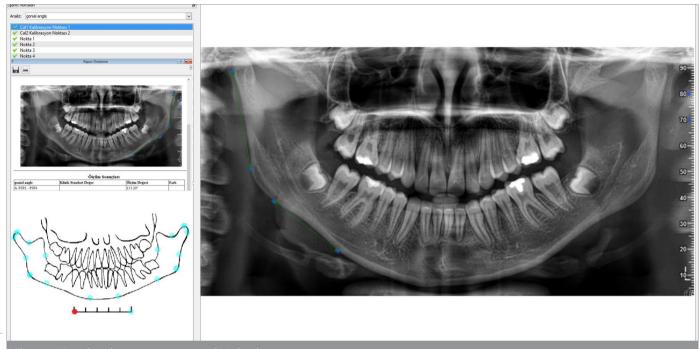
Gonial angle measurement on a digital orthopantomogram.
